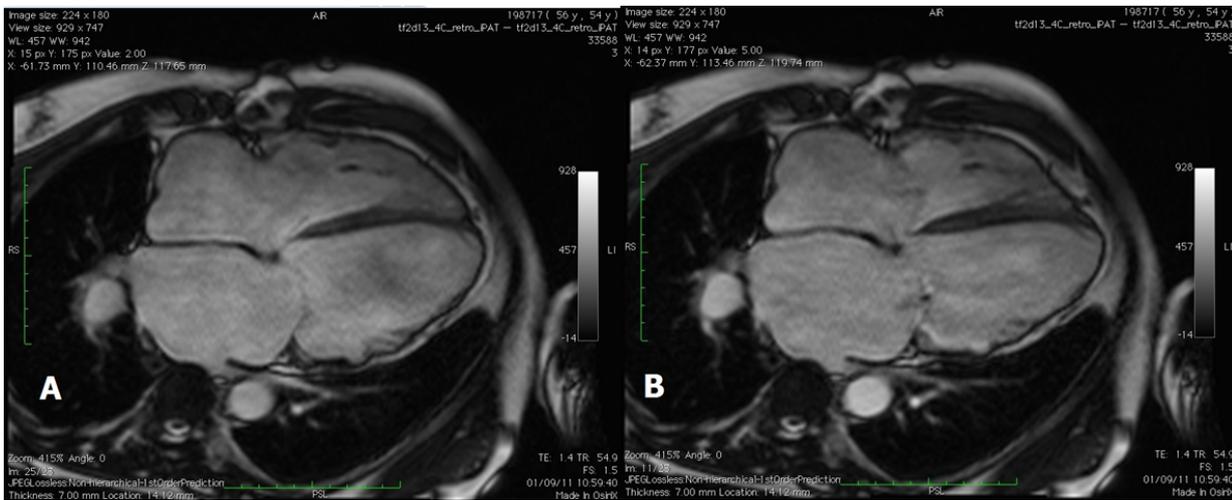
Cardiac MRI: long axis views at diastole (A) and systole (B), showing dilated heart chambers, wall thinning and severe ventricular systolic dysfunction.
